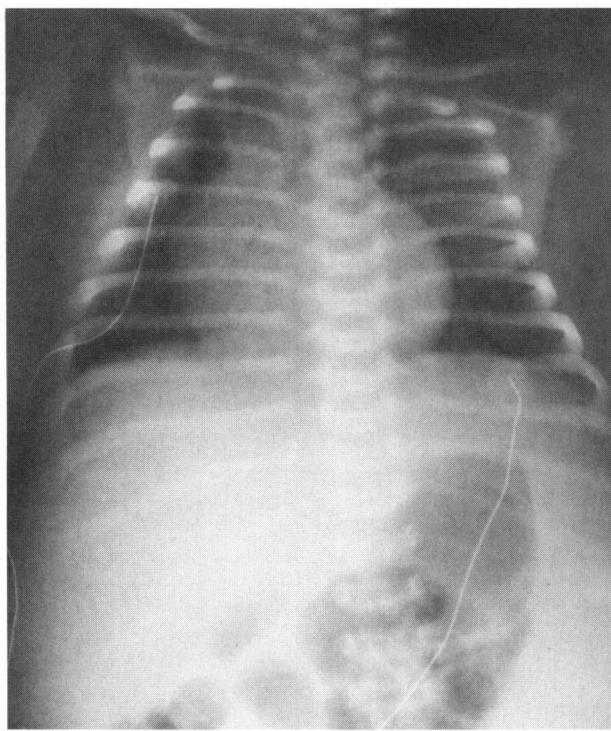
Radiograph of the Chest and Abdomen.
